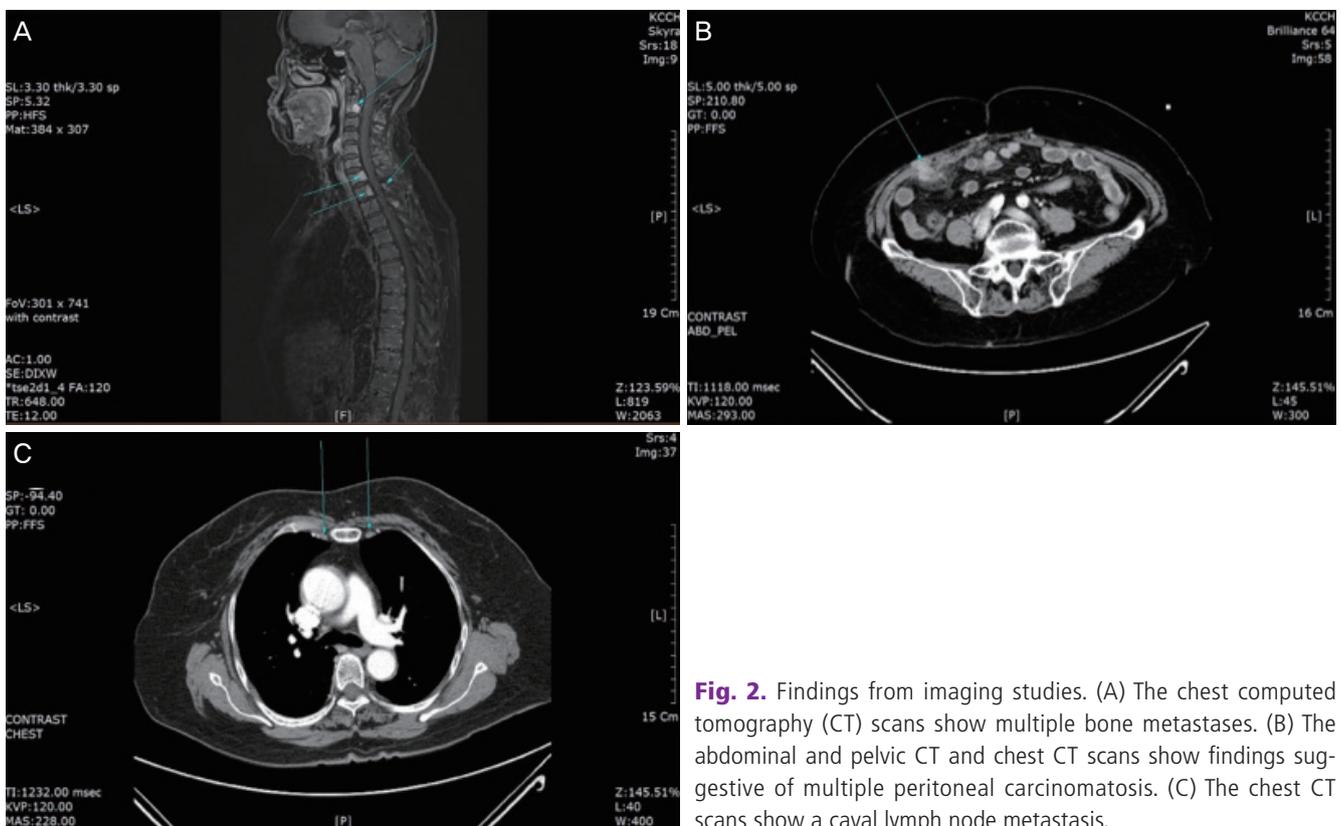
Findings from imaging studies. (A) The chest computed tomography (CT) scans show multiple bone metastases. (B) The abdominal and pelvic CT and chest CT scans show findings suggestive of multiple peritoneal carcinomatosis. (C) The chest CT scans show a caval lymph node metastasis.
